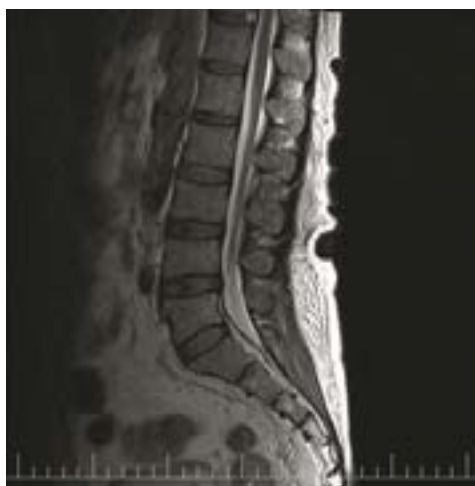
Sagittal section spinal Magnetic Resonance Images (MRI) of the Thoracic spine.
